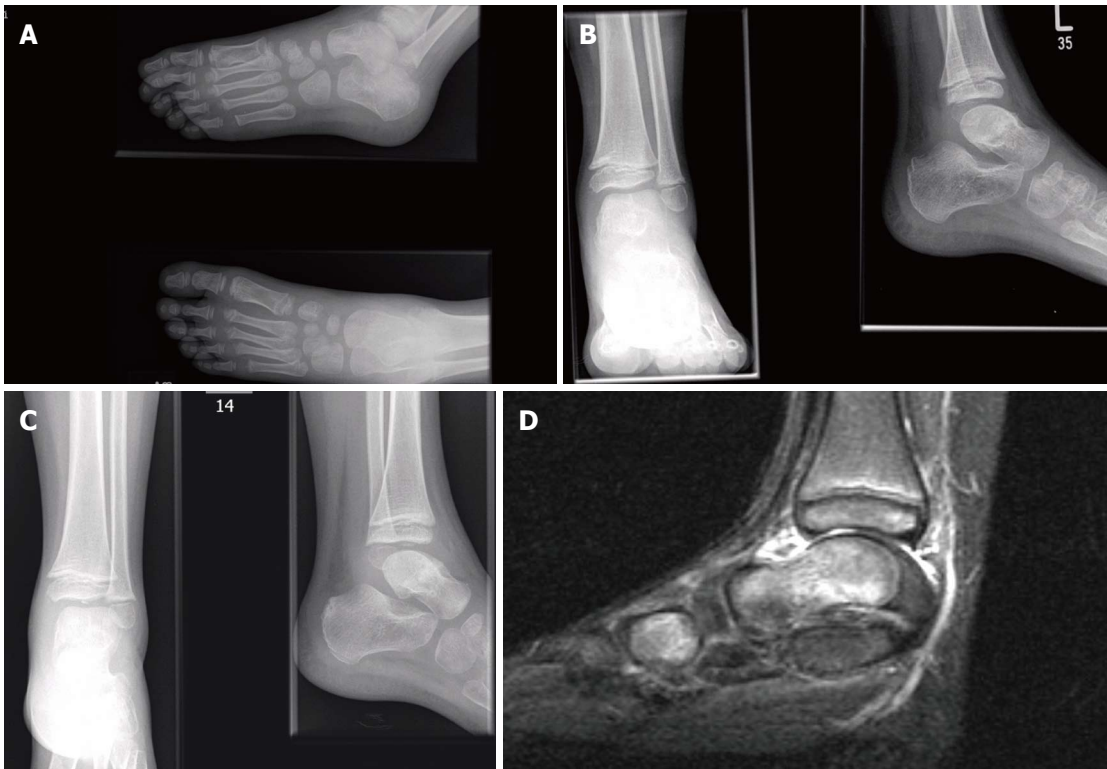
The magnetic resonance imaging scan for delayed presentation of a loose body in undisplaced paediatric talar neck fracture. A: Initial foot and ankle radiographs taken post injury in the United Kingdom showing an undisplaced talar neck fracture; B: Radiographs taken at four weeks following immobilisation in plaster showing a healed fracture; C: Repeat radiographs taken three weeks following discharge from clinic as patient returned symptomatic. A clear loose body in ankle joint is present; D: Pre-operative magnetic resonance imaging scan of ankle demonstrates a 5.5 mm loose body antero-superiorly to the left talar dome and an osteochondral defect (OCD) of the distal talar dome.
